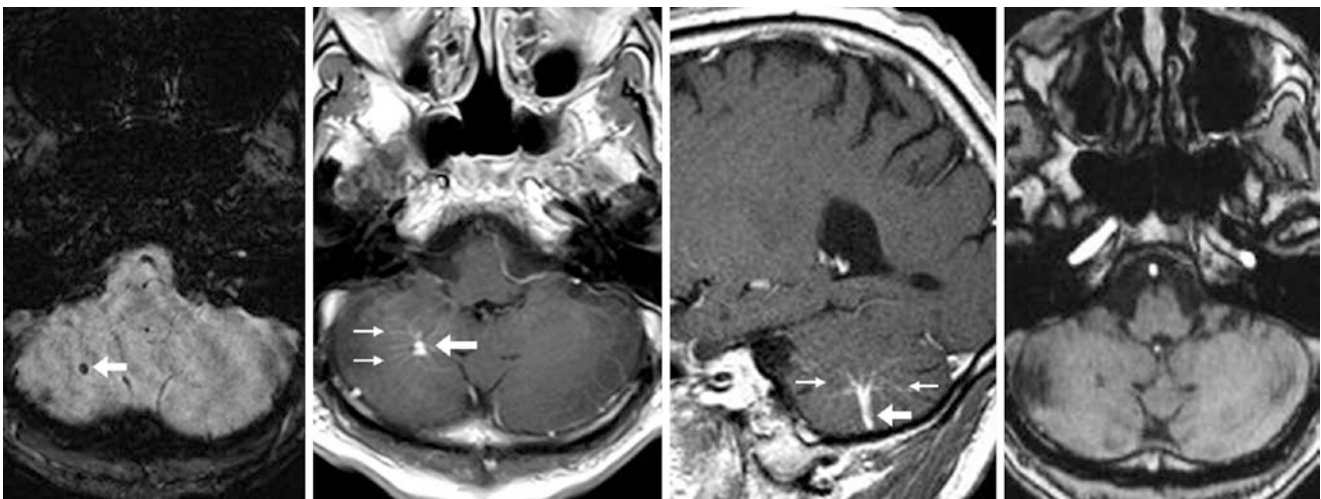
A 64 year old followed for a pituitary lesion in whom a 1.5T brain MRI noted a moderate-sized vein (*arrows*) draining inferiorly from a caput of vessels (*thin arrows*) within the right hemis cerebellum on SWI (*left*) and on postcontrast axial (*left middle*) and sagittal
